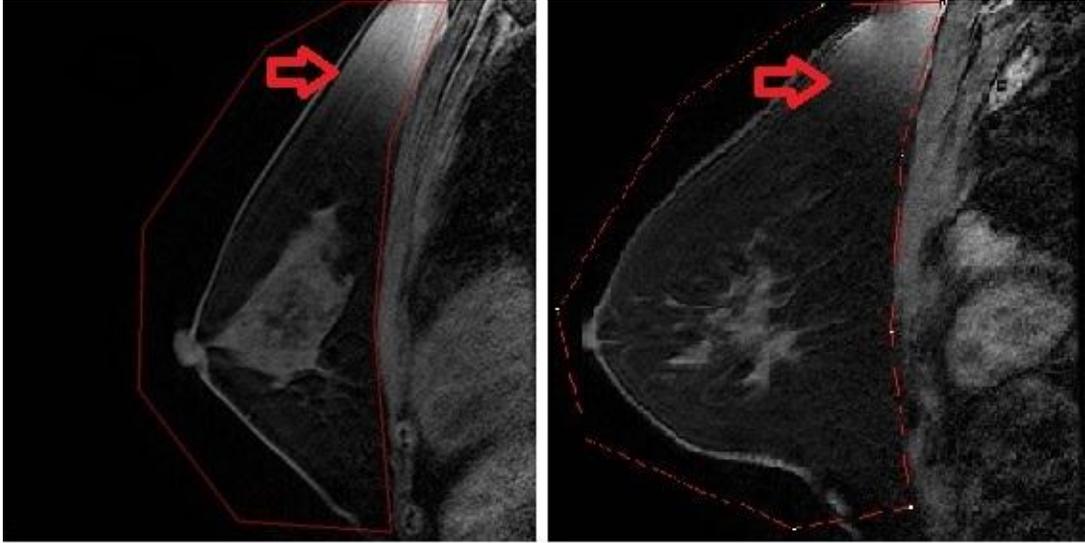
Samples of MRI images with poor fat suppression
